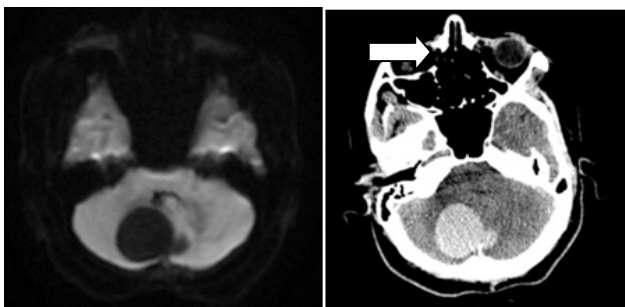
Magnetic resonance imaging - DWI sequence shows no diffusion restriction and Axial non contrast CT image shows hyperdense nature of the lesion.
